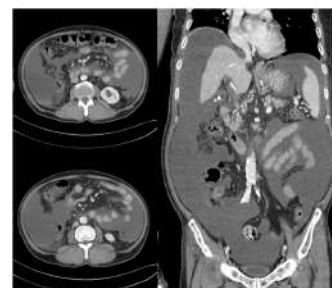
Computed tomography imaging.
